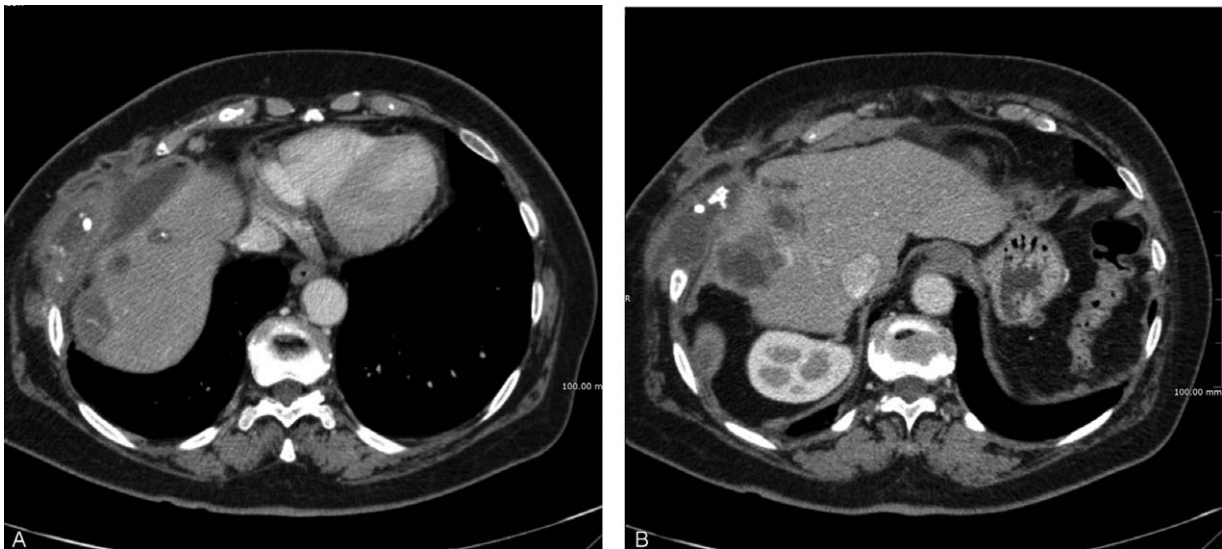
CT scan revealing multiple hydatid cysts of the right hepatic lobe involving the diaphragm, the lower pulmonary right lobe, and eroding the chest wall in a 78-year-old woman (A and B). She underwent a right hepatectomy associated to diaphragm repair with mesh, costal resection, and atypical pulmonary resection.
